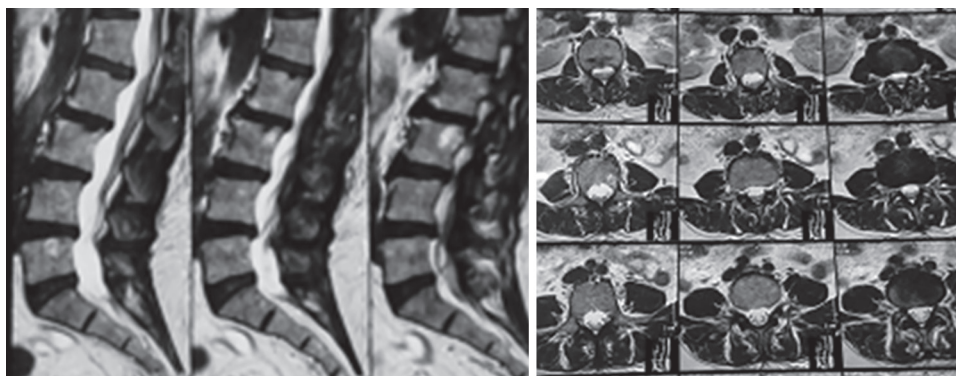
Degenerative changes at multiple levels on T2-weighted MRI
